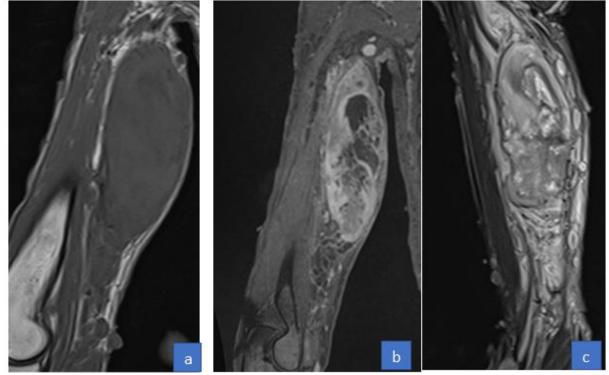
MRI of right arm a. T1, b T1 with contrast, c. STIR
